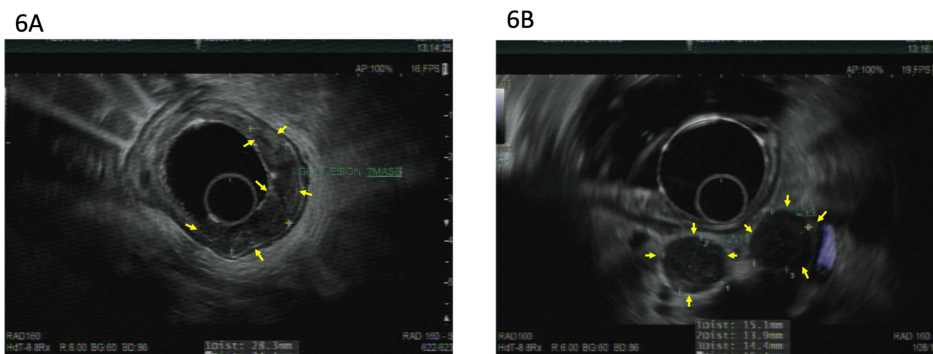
Endoscopic ultrasound (EUS) for esophageal cancers. (A) Image showing a 2.8 × 2.4-cm hypoechoic mass (yellow arrows) arising from mucosa and extending to the submucosa (layer 3) without extension to muscularis propria (layer 4). (B) EUS image with lymph nodes—this image shows two lesions that are hypoechoic, with sharply demarcated borders and rounded contours (yellow arrows). These lesions were consistent with malignant-appearing lymph nodes per EUS criteria.
